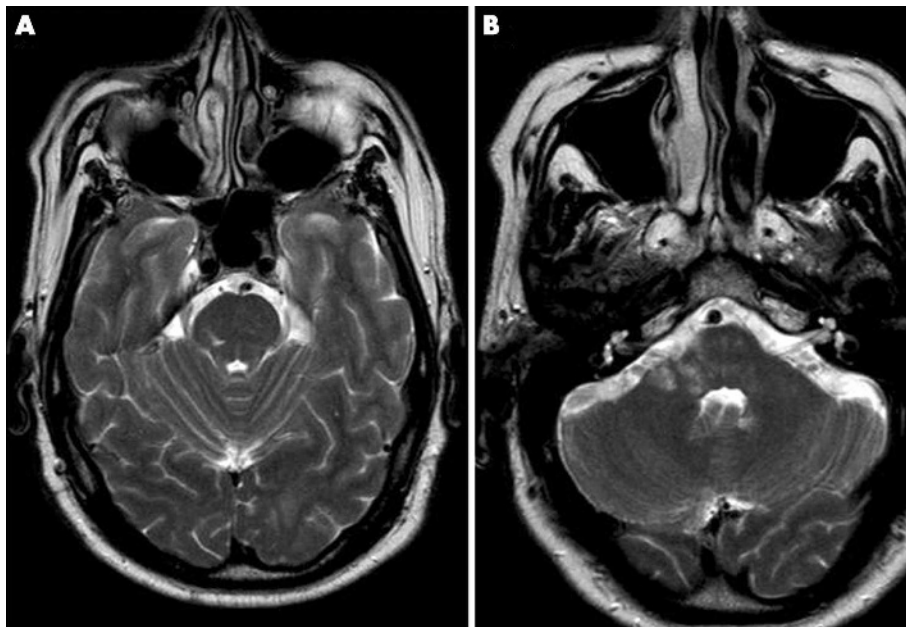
Magnetic resonance images showing a high intensity within (A) the right pons (T2 weighted sequence), and (B) the right middle cerebellar peduncle and the right cerebellum.
